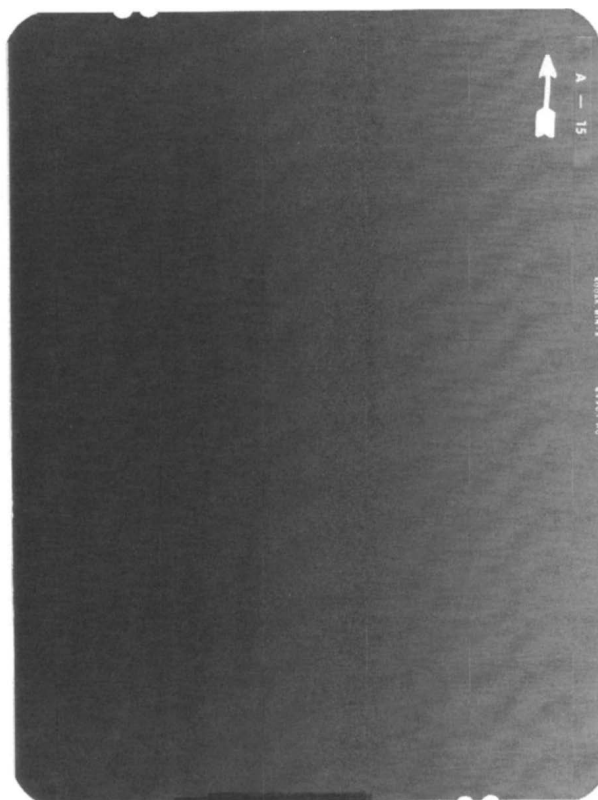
Orient the two films at right angles to one another, as in Figure 3. Any artifacts running perpendicular in the two films are due to X-ray equipment.
